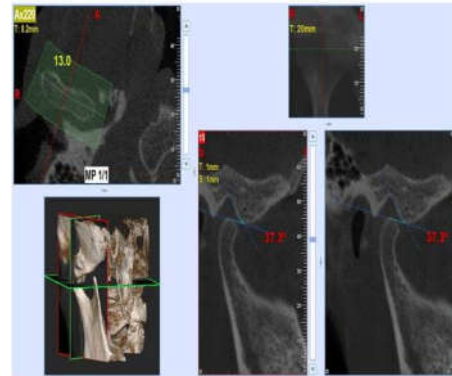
CBCT evaluation on right side
